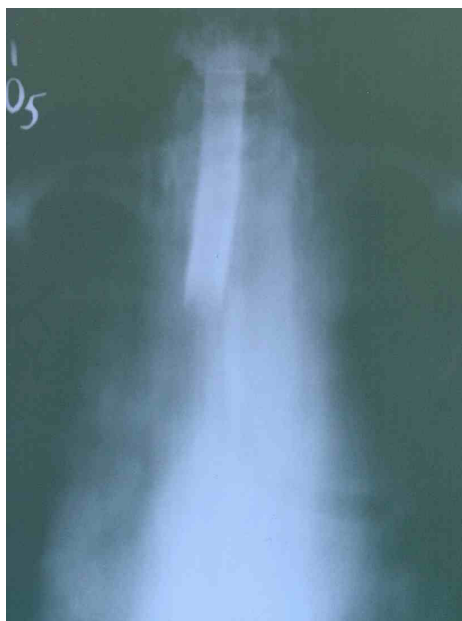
X-ray tomogram of neck and mediastinum of the patient E. The mediastinum shade is not dilated, metallic cannula is in trachea.
